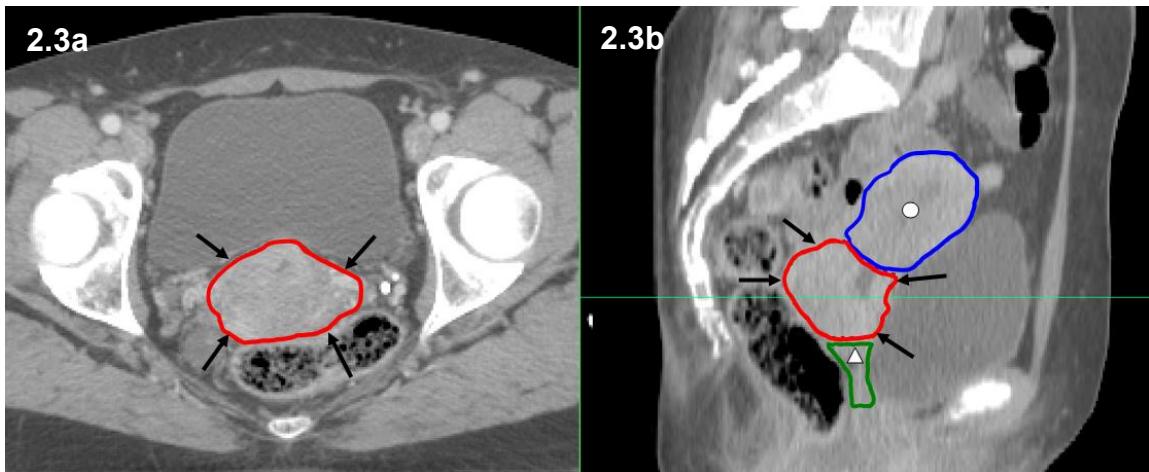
Axial (a) and sagittal (b) CT of the cervix and GTV outlined as a single structure (red); uterine corpus (circle) and vagina (triangle)
